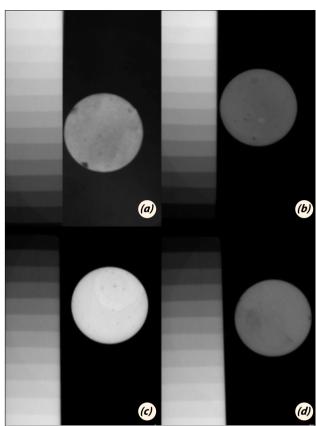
Digital radiographs of the NeoSealer Flo (a), Sure-Seal Root (b), AH Plus Jet (c), GuttaFlow Bioseal (d) root canal sealers and an aluminum penetrometer.
